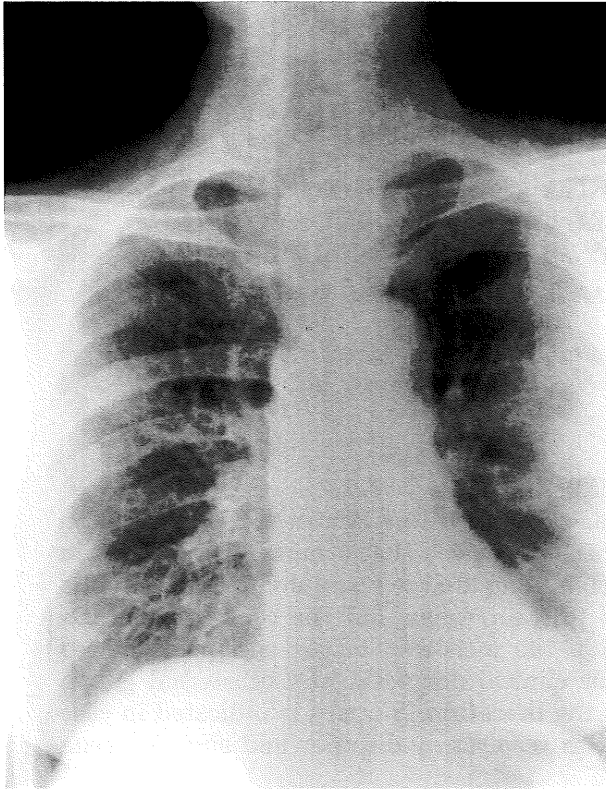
Abnormal shadow was noted in Chest X-ray in 1991.
